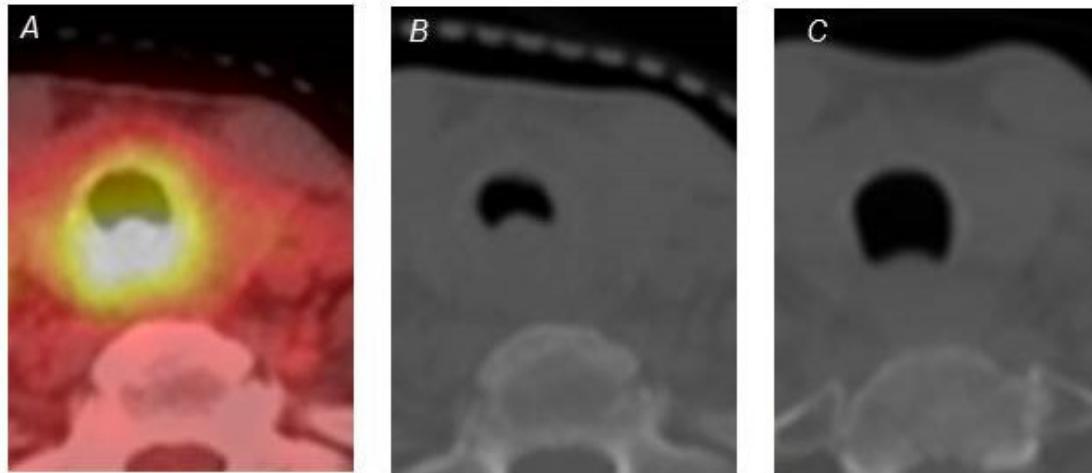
Rapid Response to Radiation. Clinical appearance of chloroma on PET (A) and CT (B) who was symptomatic with stridor who underwent 24 Gy with rapid symptomatic relief and radiographic response immediately following completion of radiation (C).
